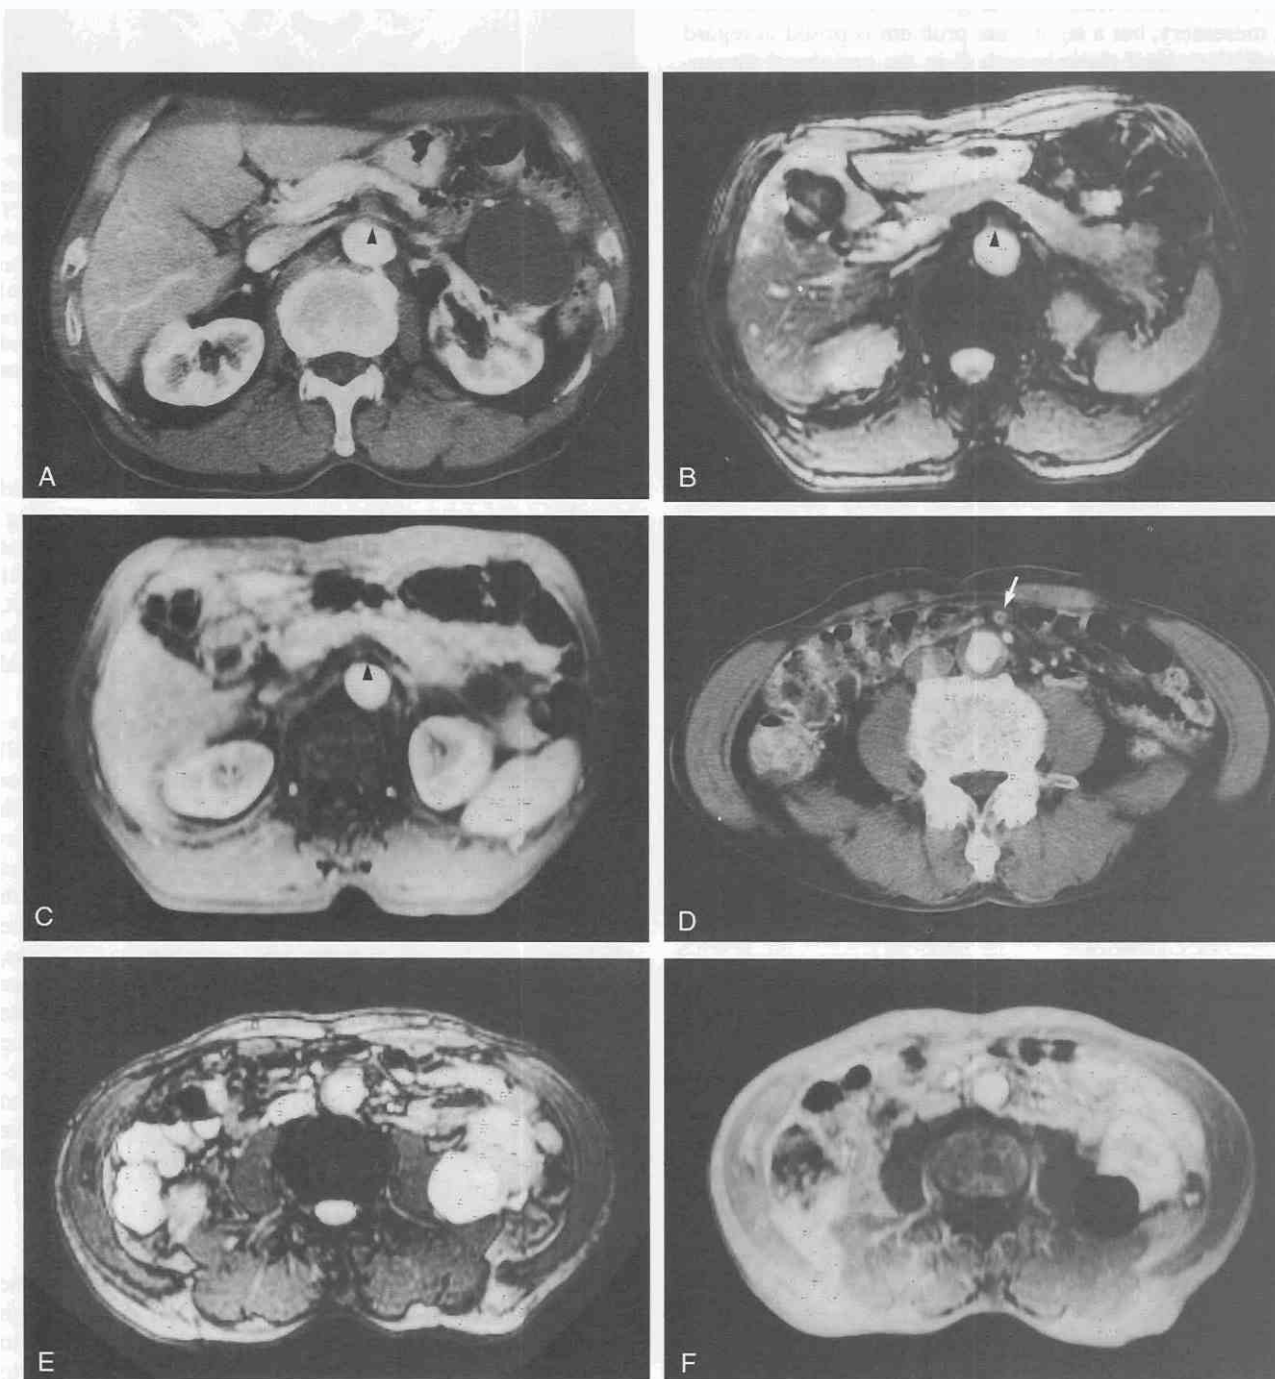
Intestinal ischemia due to multiple arterial emboli. CT scan (A) shows a hypoattenuated occlusive lesion (arrowhead) in the root of the superior mesenteric artery, which is well demonstrated on axial T2-weighted (true fast imaging with steady-state precession [FISP]) (B) and gadolinium-enhanced (C) MR images. CT scan (D) at a lower level shows a small embolus in the branch of the superior mesenteric artery; however, the embolus is difficult to see on true-FISP (E) and contrast-enhanced (F) MR images.
